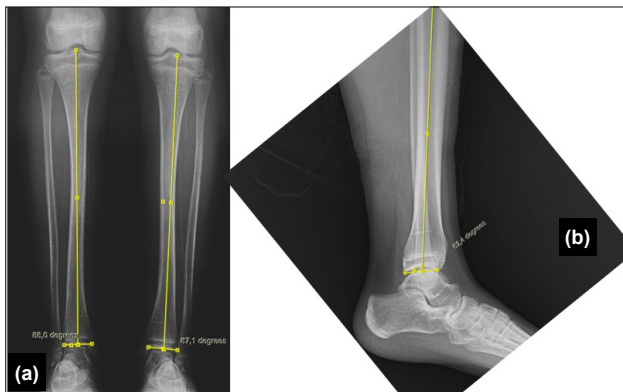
(a) The lateral distal tibial angle is measured between a line parallel to the distal tibial plafond and the mid-diaphyseal line of the tibia. (b) The anterior distal tibial angle (ADTA) is measured as the angle between the anatomical axis of the tibia and the joint line on a lateral radiograph.
